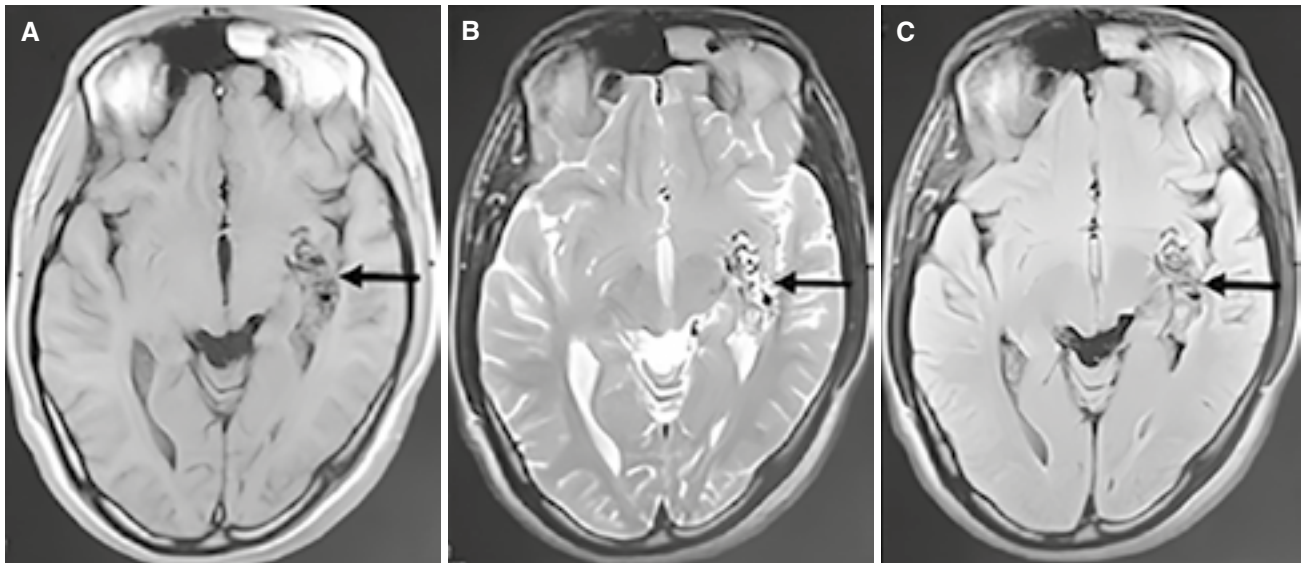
Brain MRI (T2-weighted axial section). (A) Axial noncontrast T1-weighted MR image, (B) T2-weighted MR image, and (C) FLAIR image at the level of the temporal horns, showing a cluster of serpiginous flow voids (arrows) in the left medial temporal lobe adjacent to the temporal horn of the lateral ventricle. These findings are consistent with an arteriovenous malformation (AVM) nidus, demonstrating typical signal characteristics on multimodal MRI
